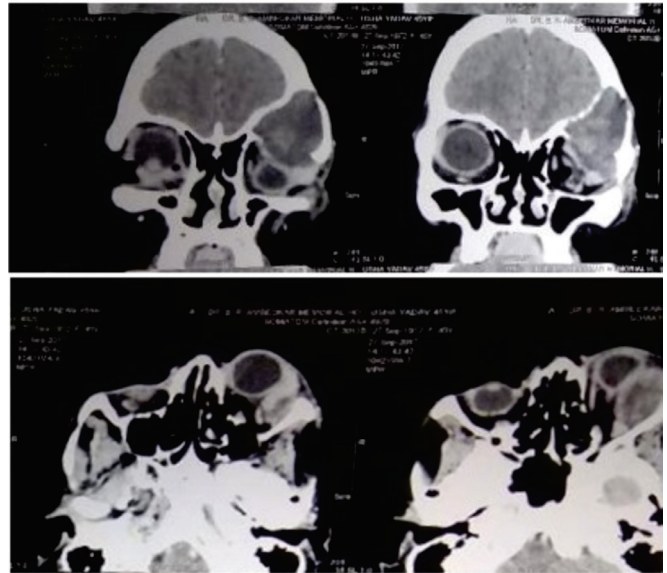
CT images showing inferomedial displacement of the eyeball by frontal mucocele
